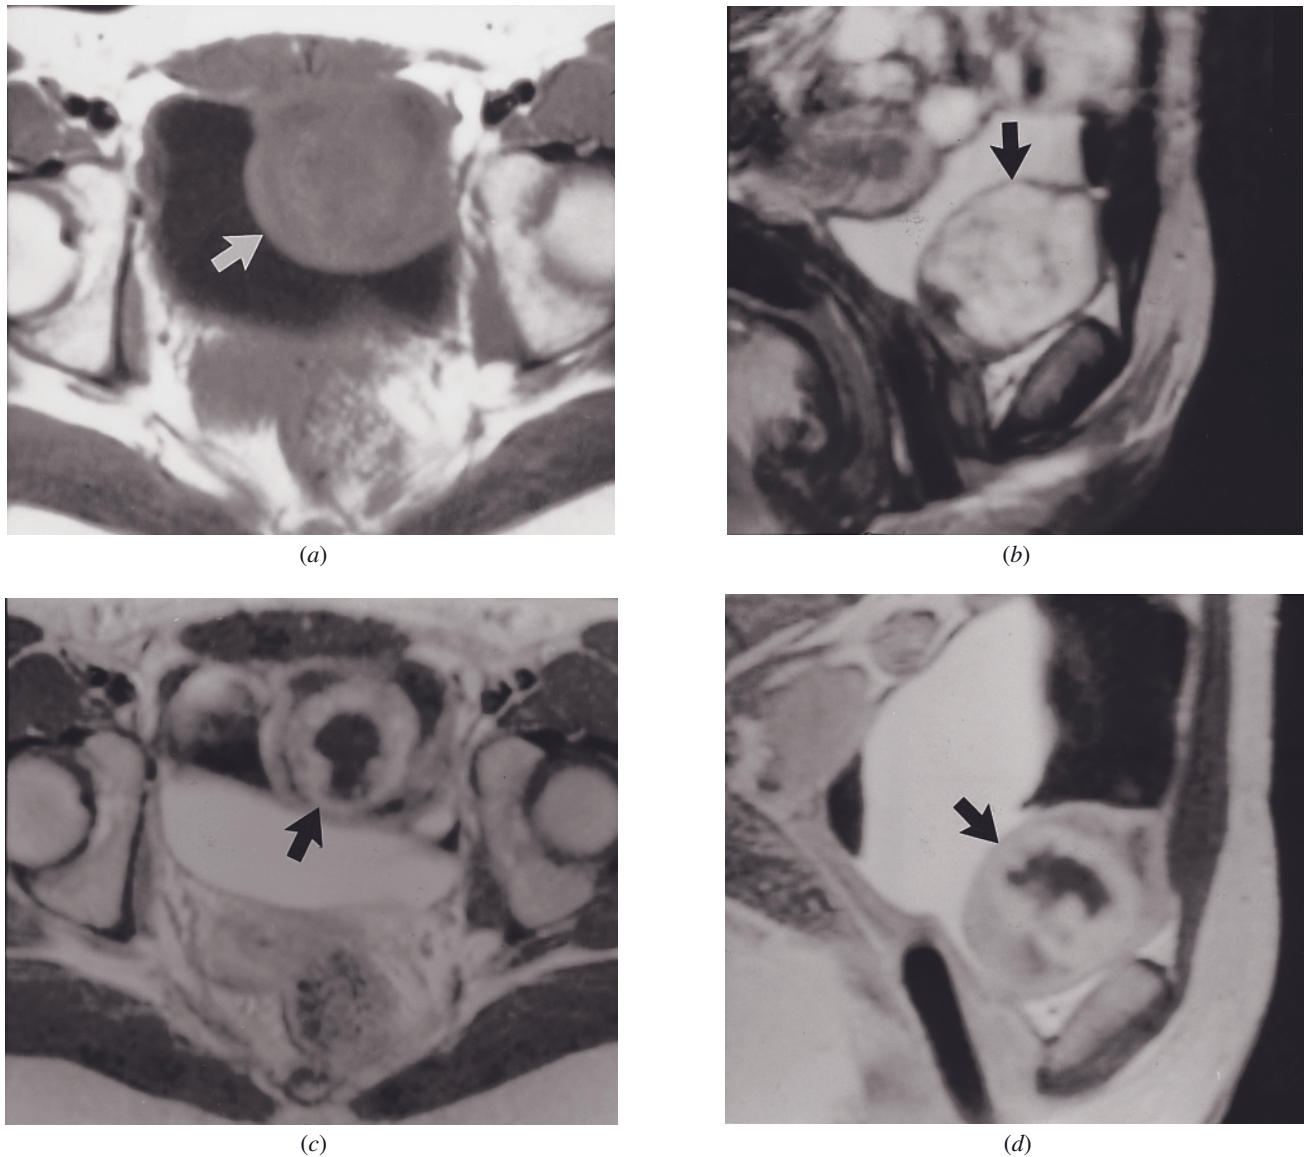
Ganglioneuroma. T1-weighted spin-echo (a), sagittal T2-weighted spin-echo (b), and transverse (c) and sagittal (d) gadolinium-enhanced T1-weighted spin-echo images. A 4-cm ganglioneuroma arises from the anteroinferior bladder wall. The tumor is intermediate in signal intensity on the T1-weighted image (arrow, a) and moderately hyperintense on the T2-weighted image (arrow, b) and shows substantial enhancement on interstitial-phase gadolinium-enhanced images (arrows, c, d) with central necrosis. (Courtesy of Hedvig Hricak, M.D., Ph.D.).
